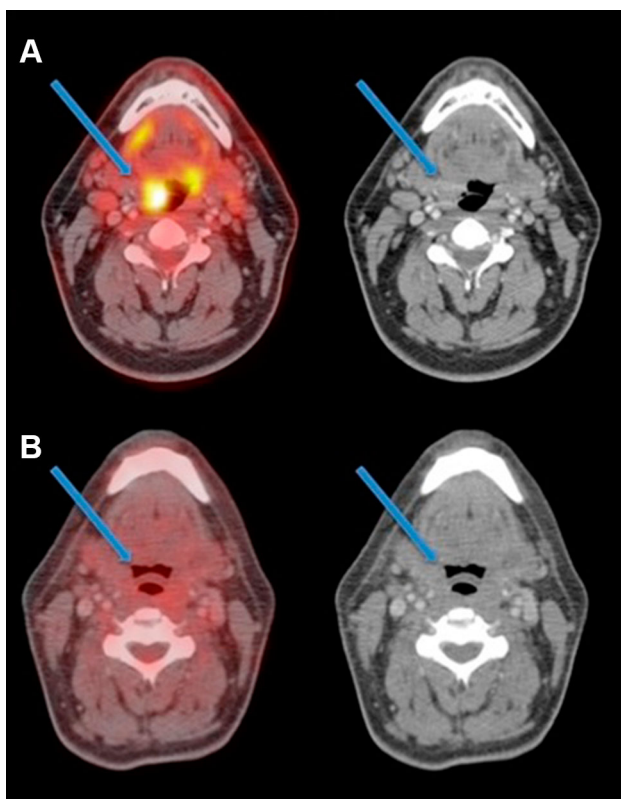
A 49-year-old female patient with a diagnosis of squamous cell carcinoma undergoing chemotherapy and concomitant radiotherapy. a PET-CT shows a nodular image, poorly delimited, occupying the right vallecula (SUVmax = 10.7), determining asymmetry of the oropharynx. b PET-CT post-treatment shows complete response, with epiglottis thickening
